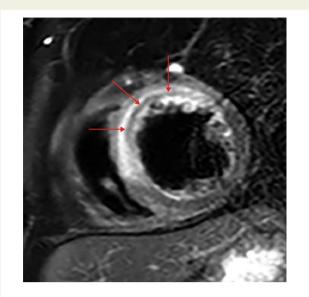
Example of an intramyocardial haemorrhage after primary percutaneous coronary intervention on T_2 -weighted magnetic resonance imaging. The hyper-intense region represents myocardial oedema, corresponding to the area at risk of infarction. The hypo-intense sub-endocardial rim corresponds to the area with intramyocardial haemorrhage (arrows)
